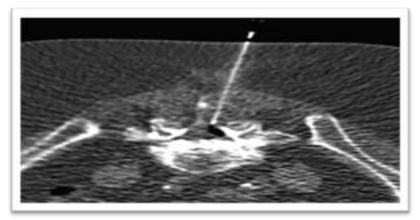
selected axial CT image demonstrate the introduction of needle in interlaminar technique
